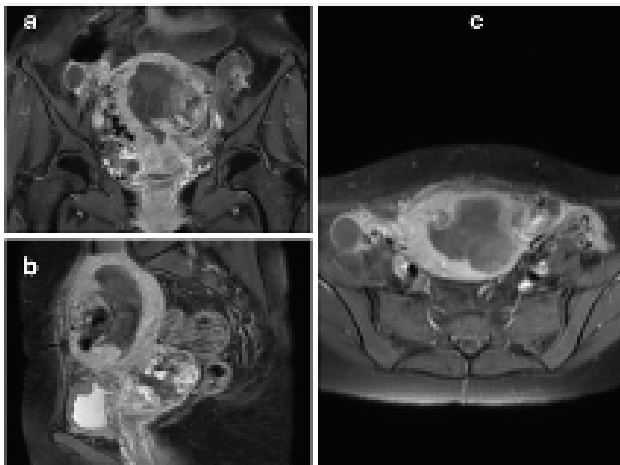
MRI of pelvis showing an enhanced bunch of vascular flow, void size $\sim 53.8 \times 88.8 \times 79.3$ mm, involving the anterior aspect of the fundus of the uterus, compressing and displacing the irregular endometrium posteriorly: a) sagittal; b) coronal; and c) axial view
